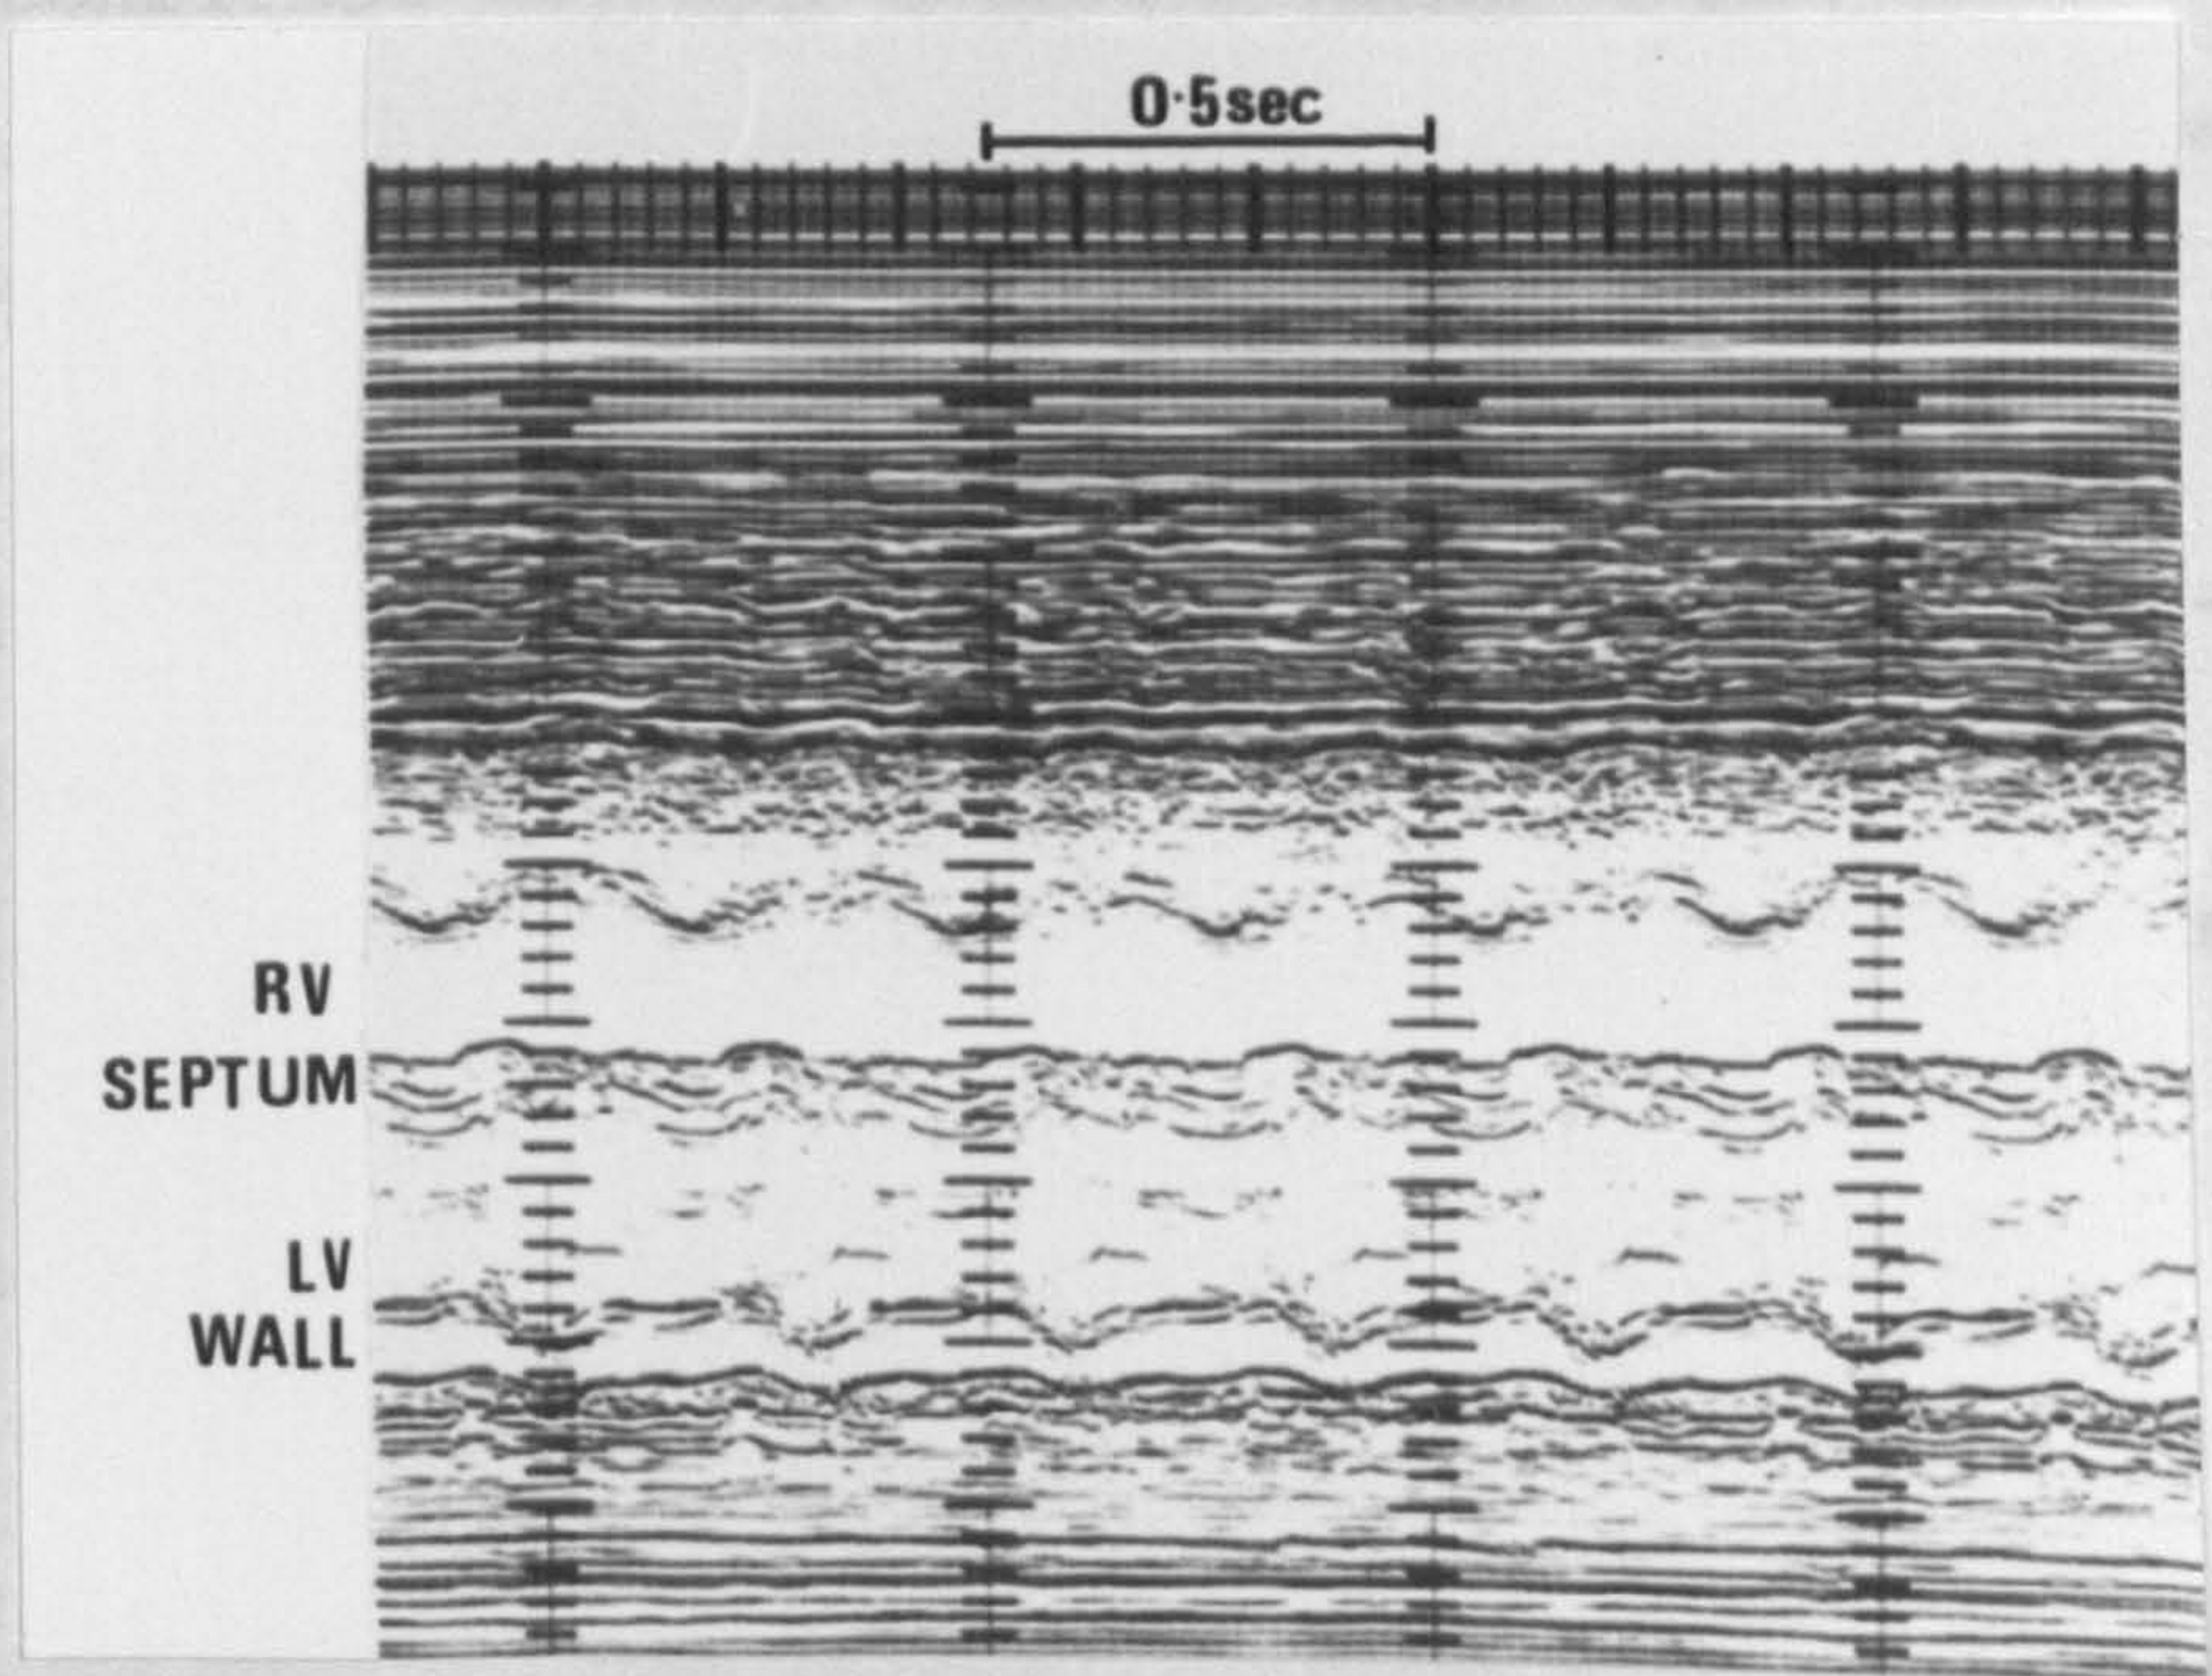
(b) Case 6. M mode echocardiogram across both ventricular chamber shows a simultaneous ventricular rate of 200/min. Note diminished movement of left ventricular wall.
